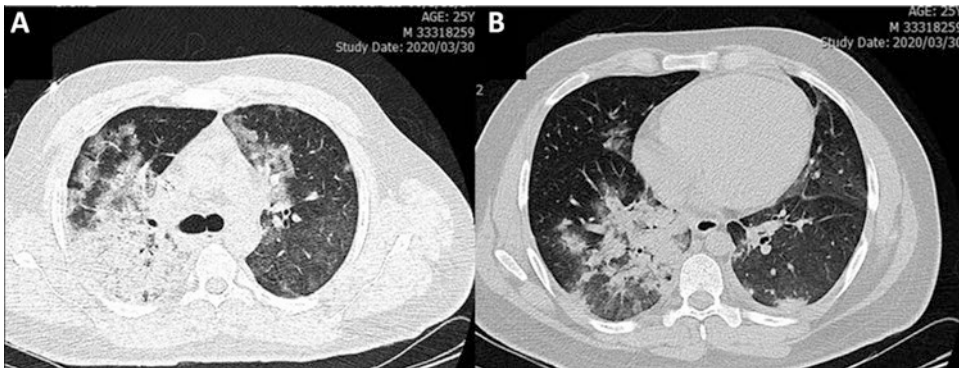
Two axial chest CT scans without contrast in a 25-year-old male with COVID-19 pneumonia show diffuse consolidative opacity in (a) right upper lobe and (b)
